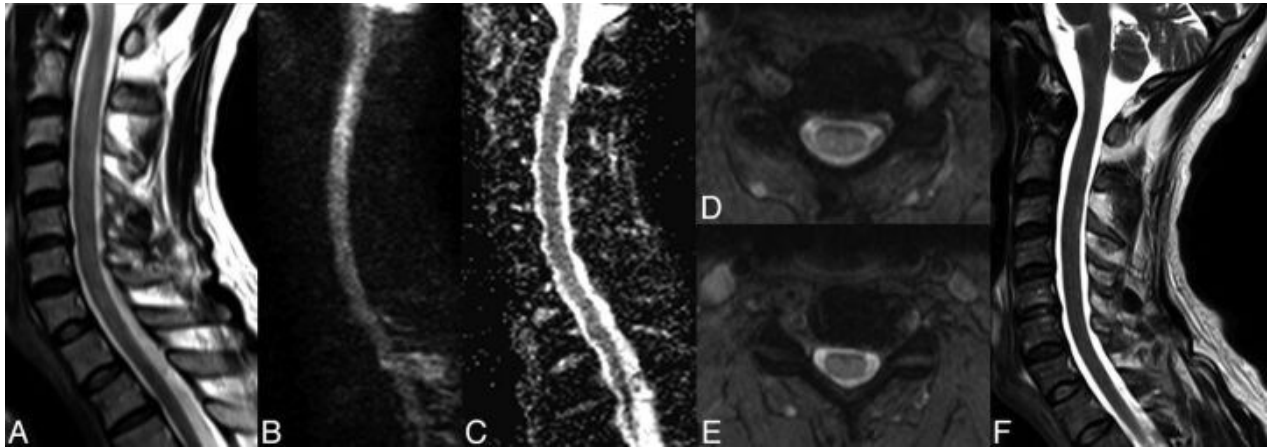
A reversible cervical spinal cord lesion secondary to decompression sickness is depicted. MR imaging reveals an extensive lesion resulting in cervical spinal cord enlargement. The lesion demonstrates hyperintensity on sagittal (A) and axial T2-weighted images (D and E), as well as on diffusion-weighted imaging (B), without a corresponding reduction in signal on the ADC map (C). These imaging findings, along with complete resolution without residual scarring, as confirmed by a follow-up sagittal T2-weighted image (F) taken two weeks later, indicate vasogenic edema, also described as an "ischemic-like" lesion. Picture from Tatuene et al.
